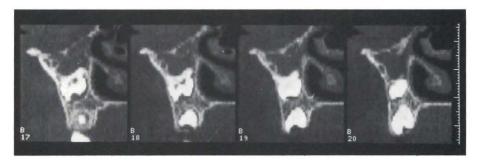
CT reconstruction of the maxilla at a buccopalatal plane, further demonstrates that the upper tooth has no root and is close to the buccal cortical bone plate, allowing safe surgery from a buccal approach.
